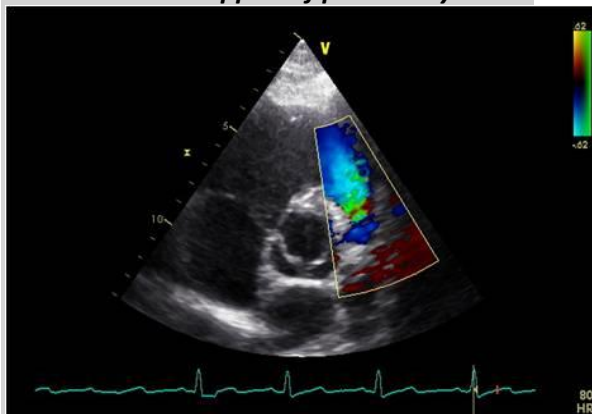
Color Doppler of pulmonary valve
